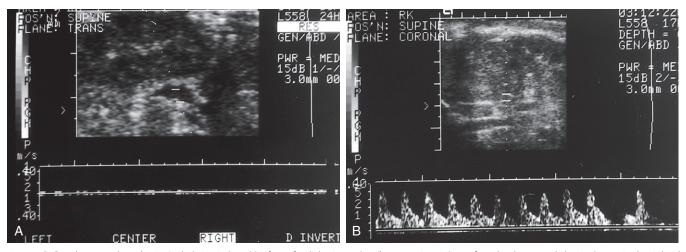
A, Renal venous thrombosis. A plethoric 2-day-old infant of a diabetic mother (hematocrit, 75%) was found to have an abdominal mass in the right abdomen on routine physical examination. Laboratory evaluation disclosed hematuria and thrombocytopenia without elevation in blood urea nitrogen (BUN) or serum creatinine concentrations. B, Notice the absence of venous pulsations in the lower panel on the Doppler study of the right renal vein while arterial pulsations remained intact. Subsequent serial renal ultrasound studies showed a progressive reduction in the size of the right kidney despite recanalization of the venous thromboses.
